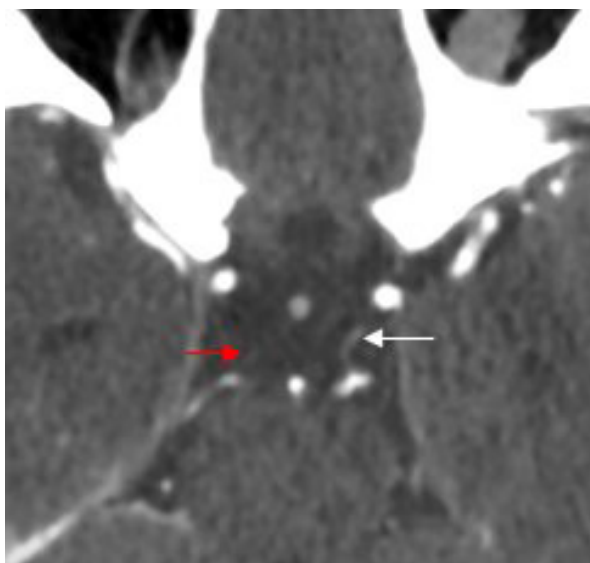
Axial image of the CTA of the brain showing right hypoplastic PCoA (red arrow). The left PCoA was normal in caliber (white arrow) and the remaining of the circle of Willis was unremarkable
